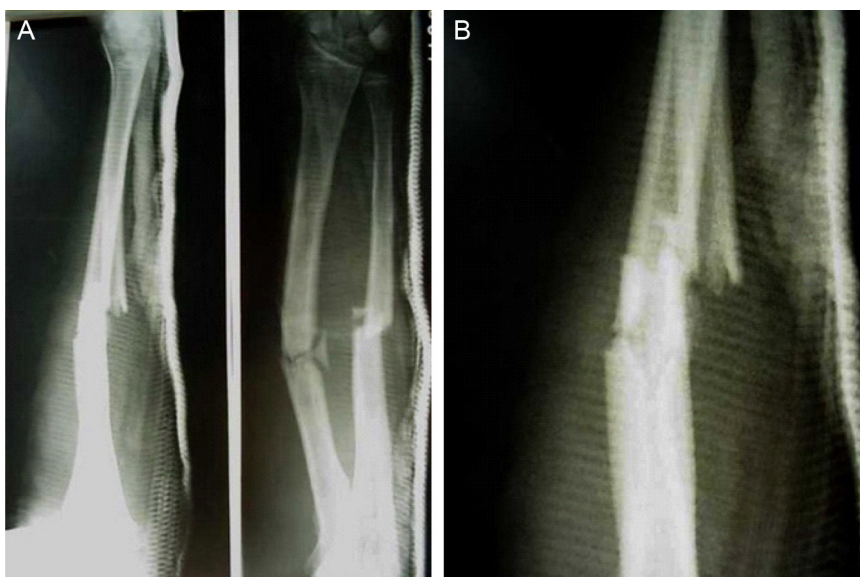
X-ray after closed reduction of forearm fracture.
